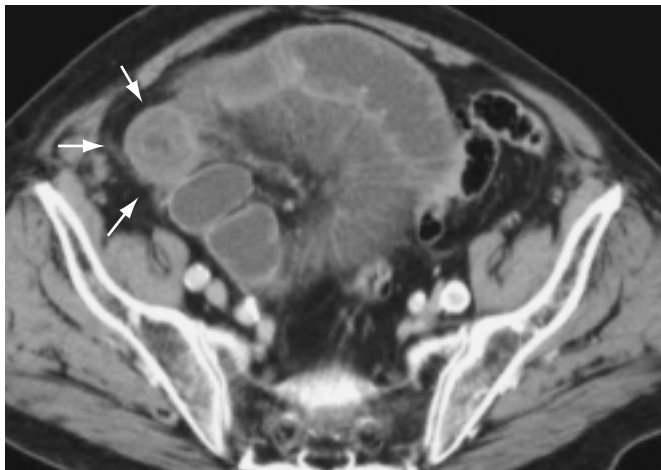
SBO from adhesions with peritoneal signs. Postcontrast CT of the abdomen showing wall thickening of the involved bowel loop (arrows).
